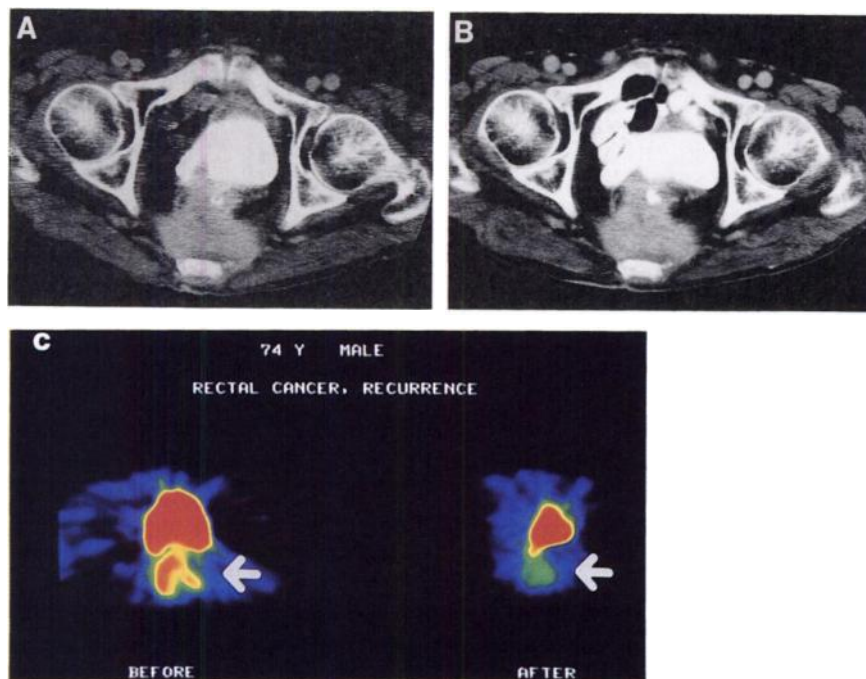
A 74-yr-old male with local recurrence of rectal cancer. The primary cancer had been resected 4 yr earlier. CT before therapy (A) showed an intrapelvic mass and high FDG uptake was also noted in the tumor (C). After radiation therapy of 70 Gy of FDG, the tumor size on CT (B) did not change, however, FDG uptake prominently decreased (C). There has been no relapse for 16 mo.
